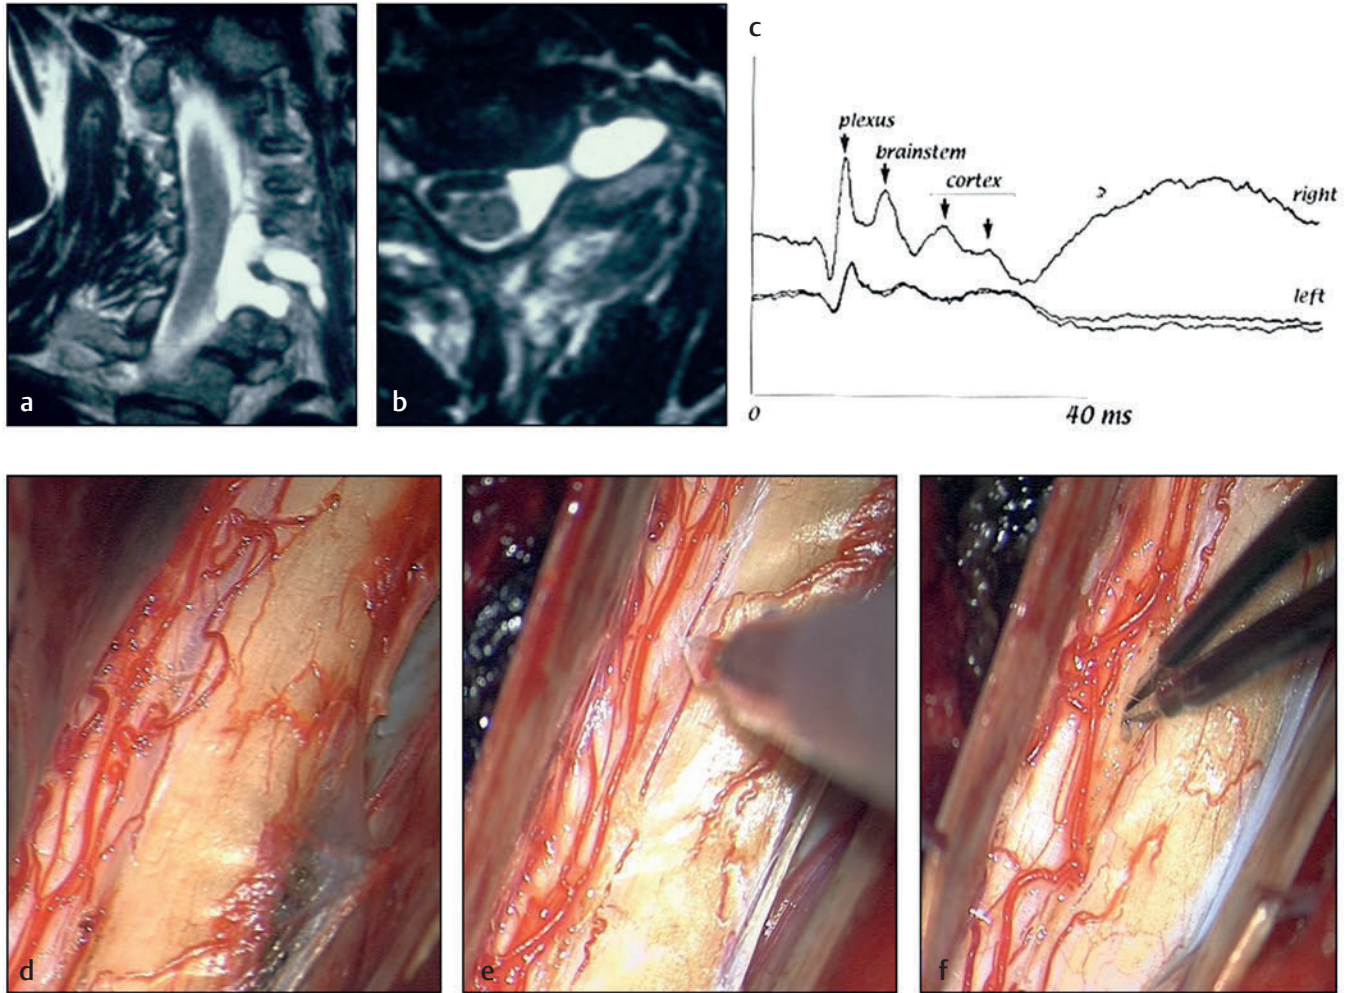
Microsurgical DREZotomy (MDT) for brachial plexus avulsion. MDT at the cervical level for C6–T1 brachial plexus avulsion on left side. (a, b) T2-weighted MRI (magnetic resonance imaging) shows pseudomeningoceles at the lower cervical spine on left side. (c) Somatosensory-evoked potentials (SSEPs) after median nerve stimulation are abolished from cervical spinal cord up to cortex on left side, compared to right side. (d–f) Operative views show total avulsion from C6–T1 on the left side. (d) Dorsolateral sulcus (DLS) can be easily identified. (e) Incision into the DLS is made with a microknife. (f) Dotted microcoagulations into the dorsal horn, which has a gliotic aspect, are performed 3 mm inside the sulcus with the graduated bipolar microforceps.
